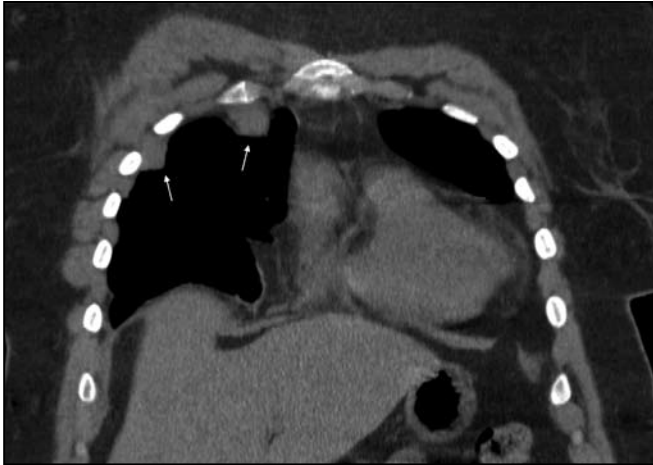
Coronal reconstruction of nonenhanced computed tomogram of the chest reveals two pleural masses, the lower of which demonstrates chest wall invasion (arrows).
